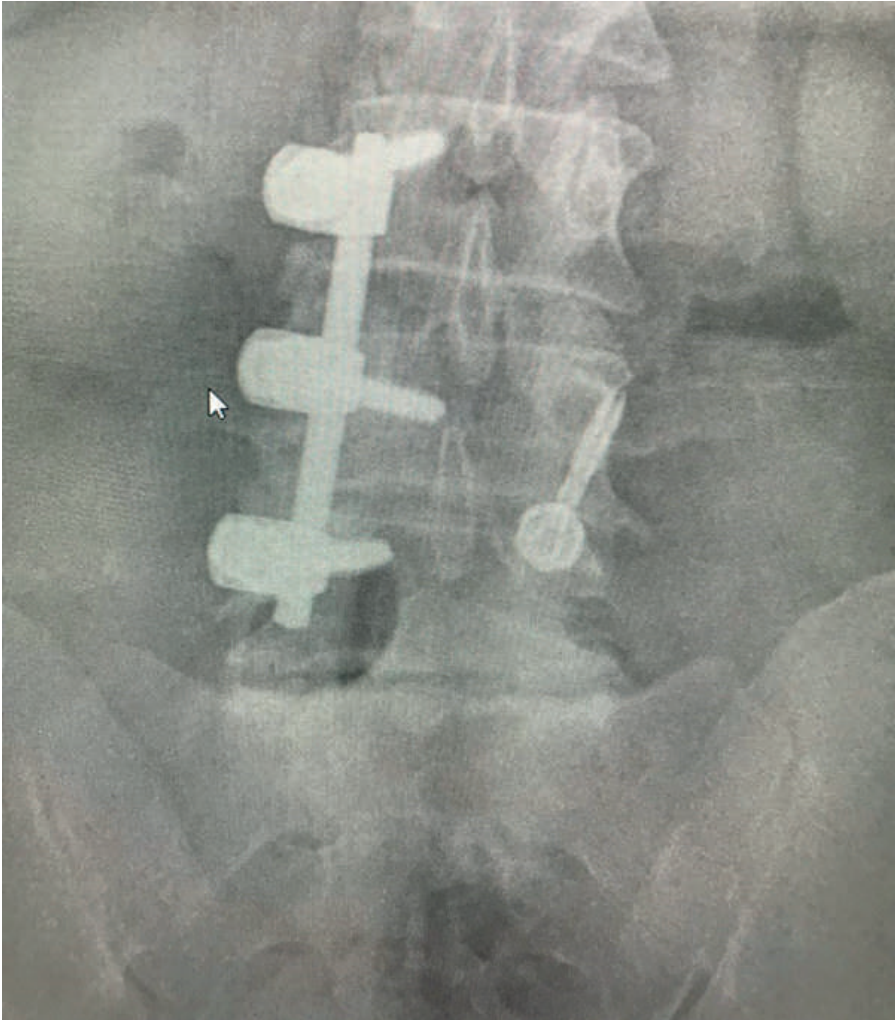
Postoperative radiograph demonstrating combined stabilization procedures. Anteroposterior lumbar spine radiograph of a 53-year-old female patient showing right-sided L3–L5 posterolateral stabilization performed for rotational scoliosis. On the left side, percutaneous fixation was performed at the L4 level for treatment of spondylolysis. The image demonstrates the coexistence of unilateral posterior instrumentation for deformity correction and percutaneous fixation for pars stabilization.
